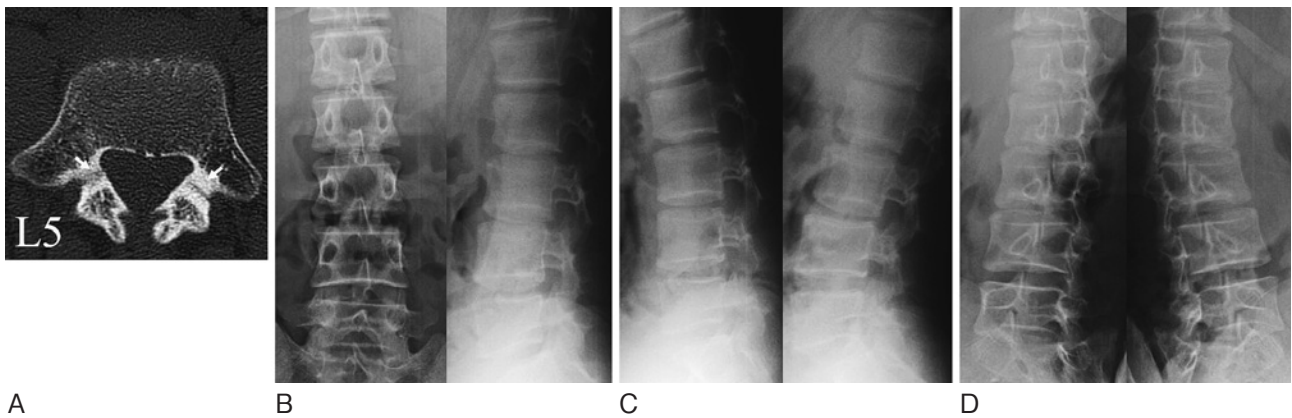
A reconstructed CT scan and plain radiographs for a 16-year-old boy with early spondylolysis. Staging of the fracture line was based on CT findings using reverse-gantry angles on the plane parallel to the pars interarticularis. (A) An oblique-axial CT scan shows a fissure-like hairline fracture in the pars interarticularis (arrow). (B-D) Plain radiographs including anteroposterior, lateral (B), dynamic lateral views (C) and oblique views (D), on which the fracture line is barely discernible.
